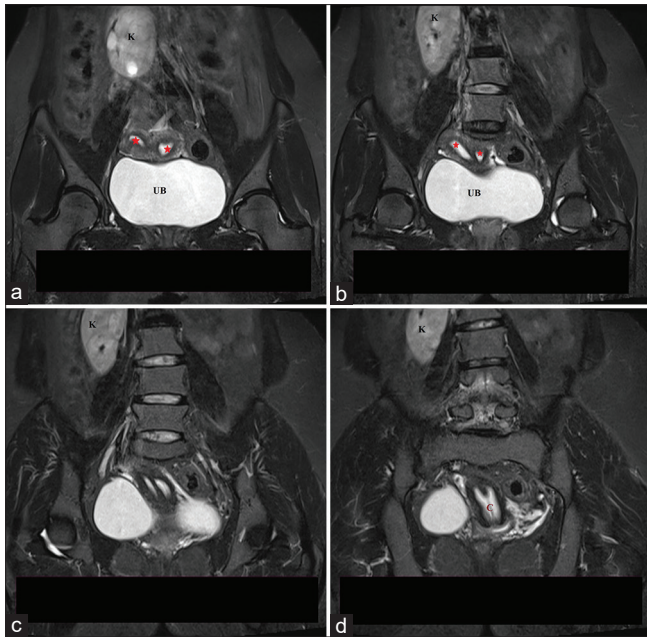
Magnetic resonance imaging of the abdomen and pelvis in coronal plane showing two uterine cavities (star) with single cervix (c). There is absence of kidney (k) in the left renal fossa. The left kidney was seen in the right renal fossa and fused with the right kidney forming S-shaped configuration. UB: urinary bladder, C- cervix
